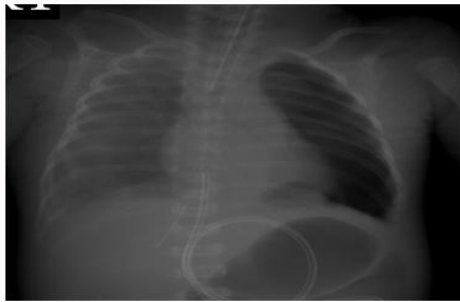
X-ray showing pneumothorax on left side. Note the position of orogastric tube (it is going towards right side).
